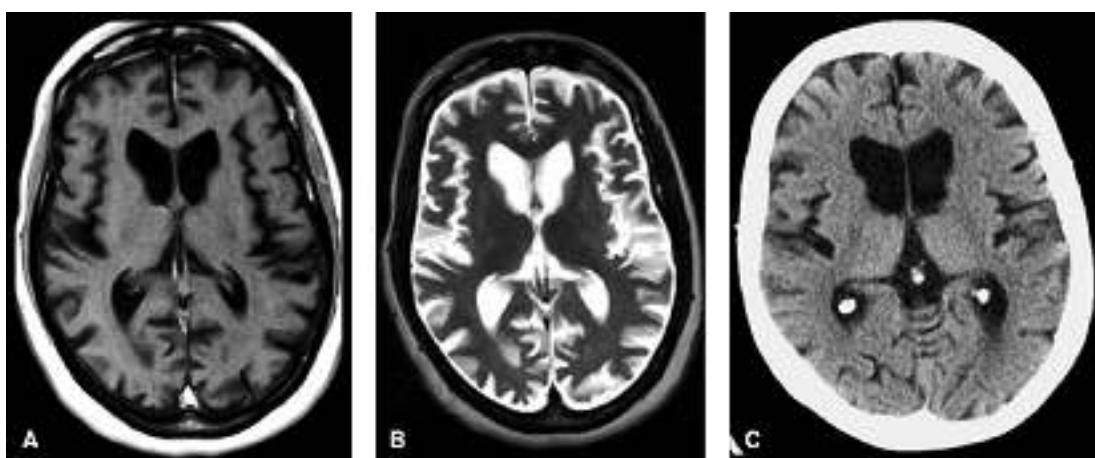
T1-weighted MRI (A), T2-weighted MRI (B) and axial CT (C) images show atrophy of the caudate and frontal horn enlargement. (From Sethi KD. Magnetic
